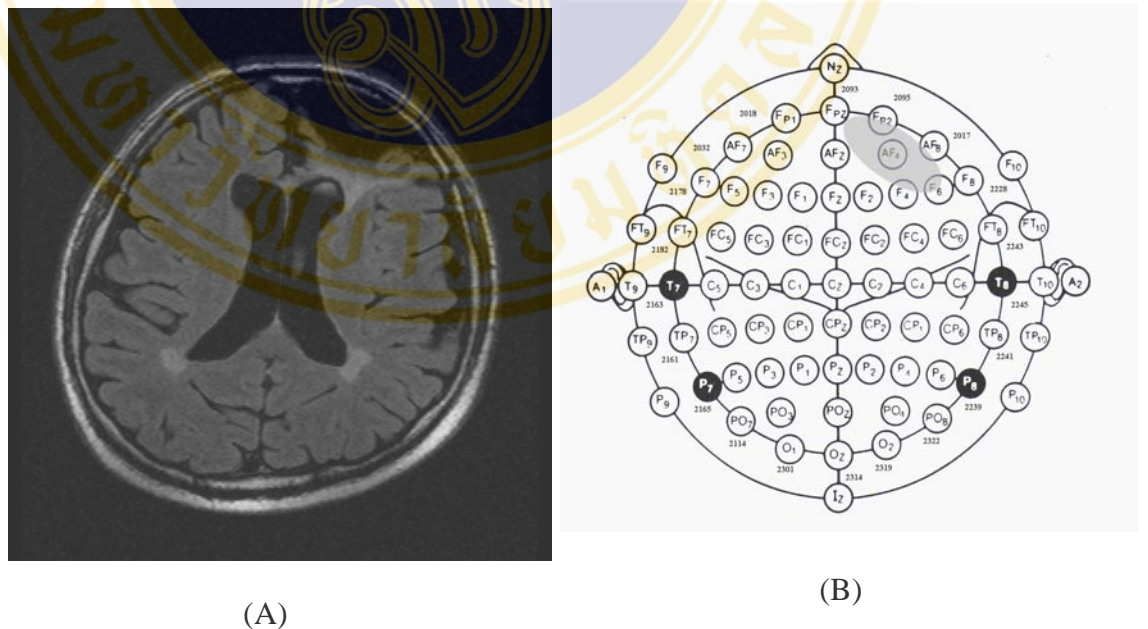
(A) 2D MRI with edema on the frontal lobe of right cerebral hemisphere, (B) The edema location on the 10-20 systems
